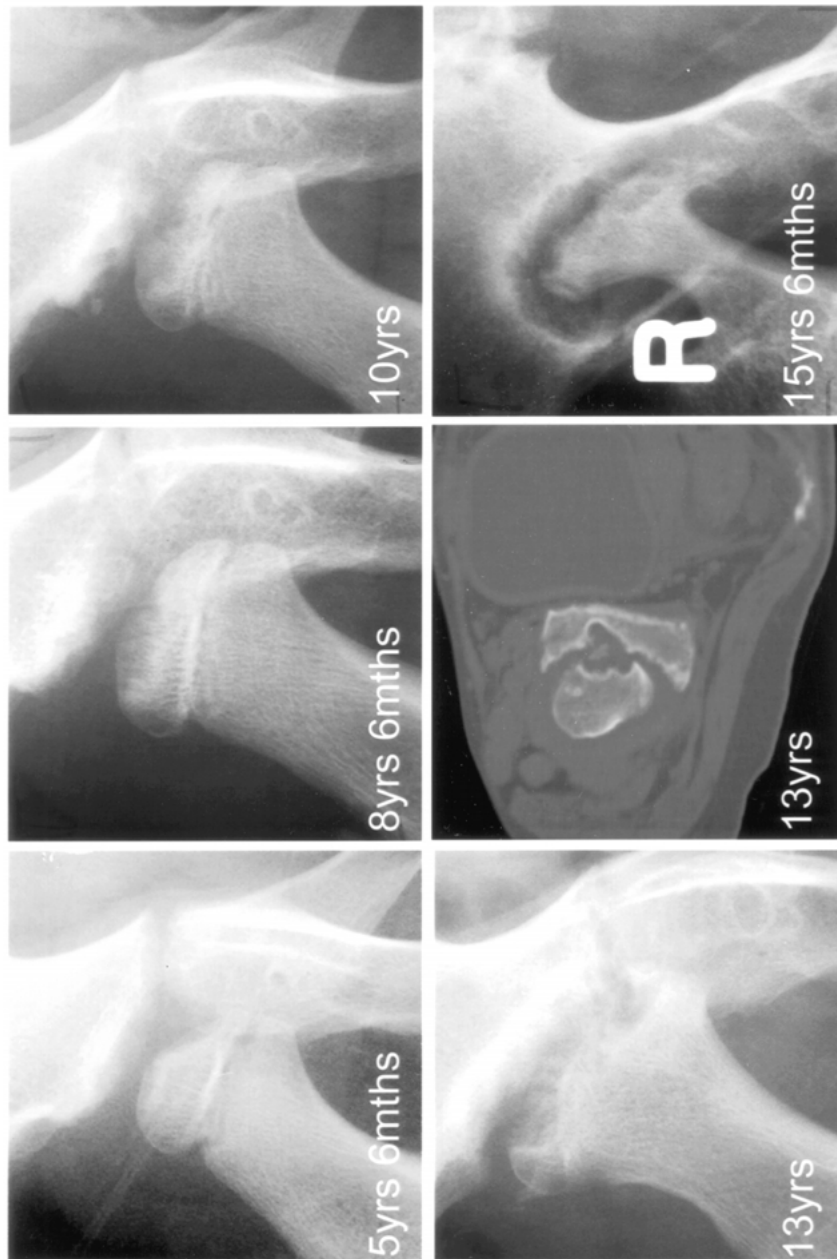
Radiographs of the right hip of subject B taken at ages 5½, 8½, 10, 13 and 15½ years, showing progressive erosion of the femoral head and the acetabulum. The final image, obtained after one year's pamidronate therapy, shows increased radiographic density but persistence of the erosive changes. The CT picture taken at age 13 years shows active bone destruction both of the femoral head and the acetabulum. The appearances were similar in subject A
